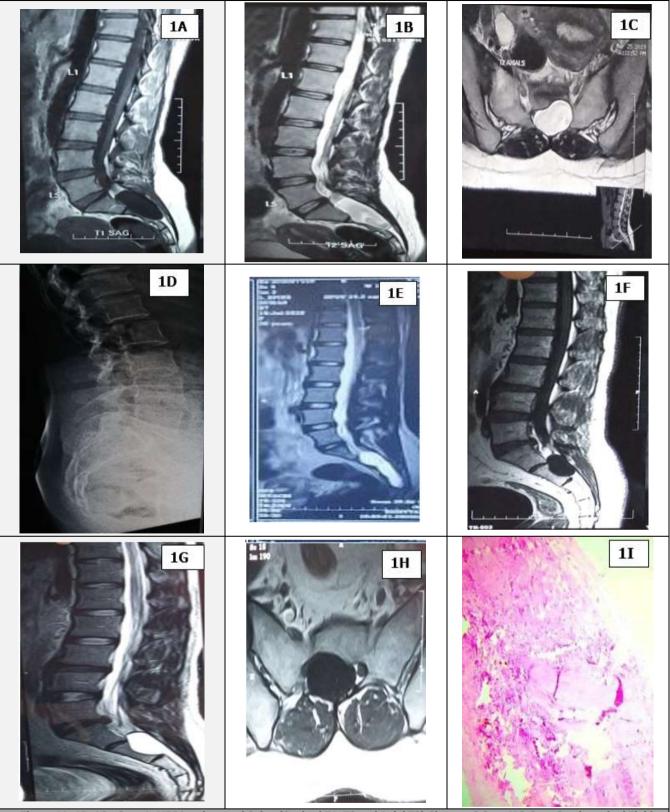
1B, 1C - Case 1: MRI Lumbosacral Spine (Sagittal T1, T2 and Axial T2) Shows a 3.2 cm X 2.6 cm Cerebrospinal Fluid Intensity Lesion Extending Dorsally from S1-S3 with Thecal Sac Compression and Mechanical Scalloping Effect on S1 -S3 Vertebrae.
